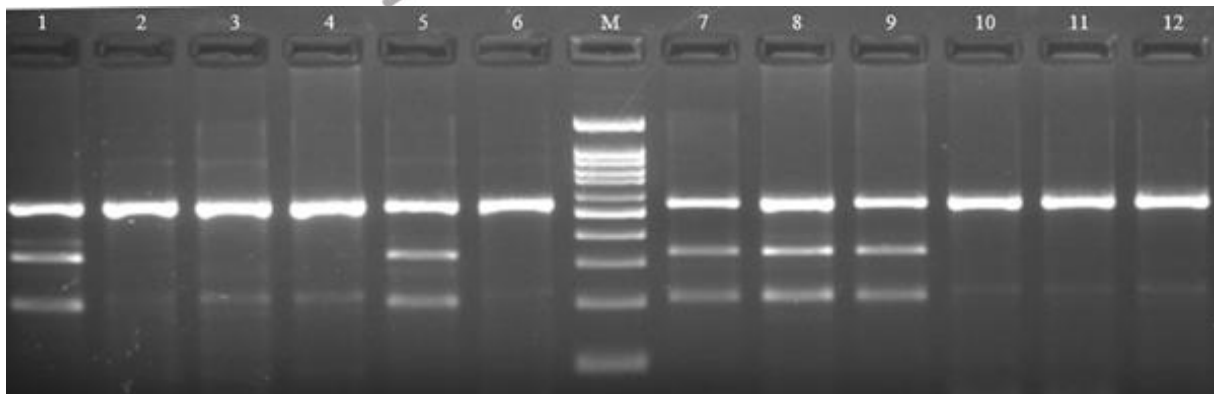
Digestion results of miR-125a gene polymorphism: The well in the middle contains 100 bp marker (M). BseSI enzyme digests 539 bp product to 329 bp and 210 bp when has C allele. Wells that contain 539 bp product have TT genotype (i.e. 2. patient) and wells that contain 539 bp, 329 bp and 210 bp products have CT genotype (i.e. 1. patient). Results have not CC genotype in both patients and controls.
